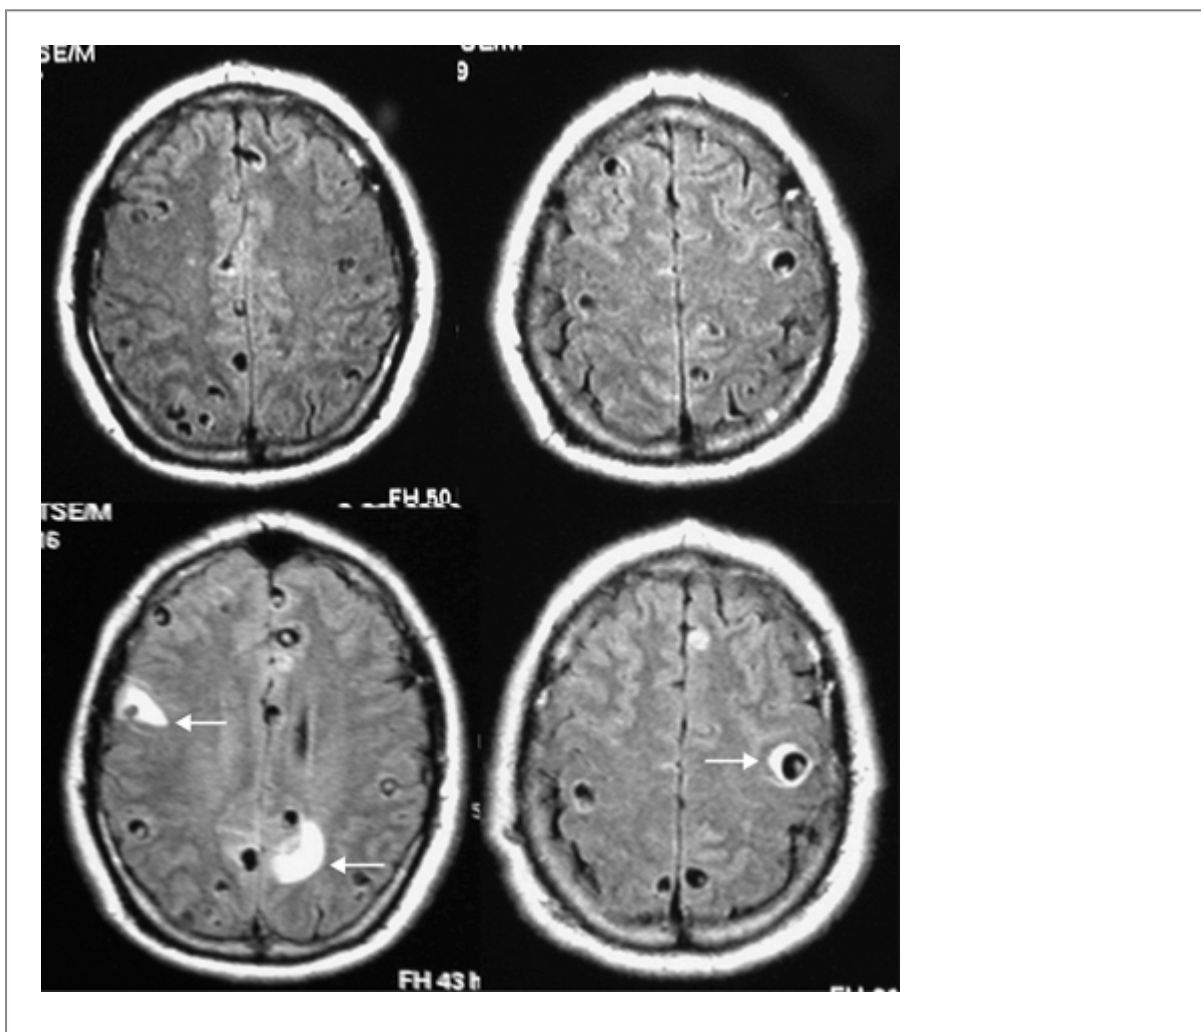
Fluid attenuated inversion recovery MRI of patient with parenchymal NCC before (*upper panel*) and 6 hours after (*lower panel*) a seizure episode, showing new hyperintense areas in brain parenchyma, some of which are surrounding cystic lesions (*arrows*).
